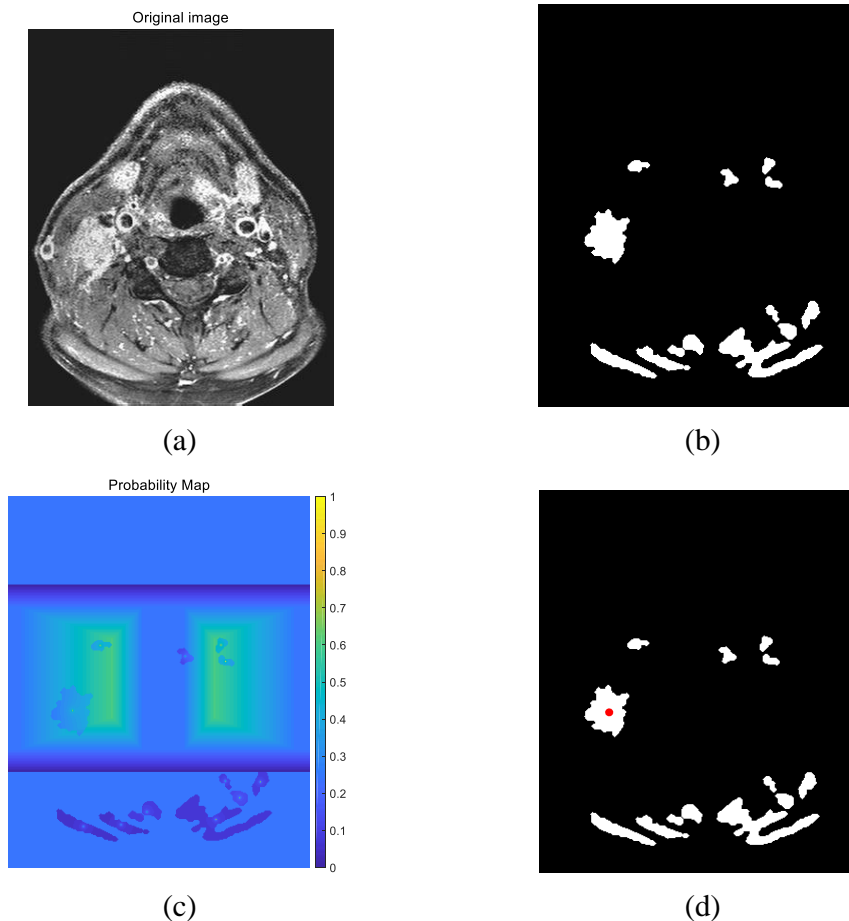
Detection of abnormal lymph nodes using probability map  $W$ . (a) An original MRI slice (MR28082014). (b) Rough ROIs in  $I_B$ . (c) Map  $W$  applied on  $I_B$ . (d) Binary regions in  $I_B$  with detected ALN (marked with red point).
